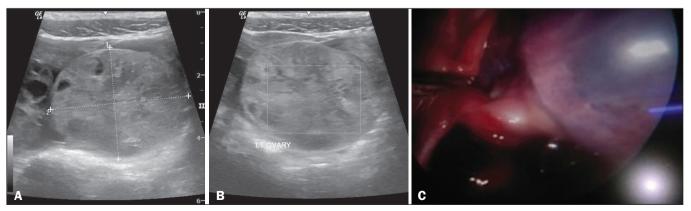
A: Ultrasound showing enlarged echogenic left ovary. B: No vascularity seen in the left ovary on color Doppler. C: Laparoscopic appearance of the left ovary.
